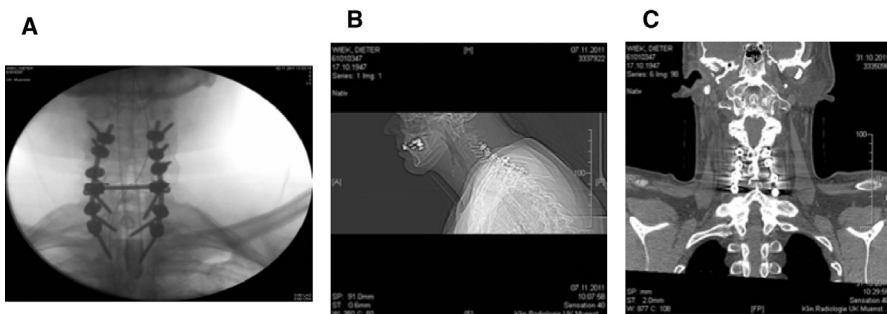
(A–C) Vertebrae fractures radiographs.
